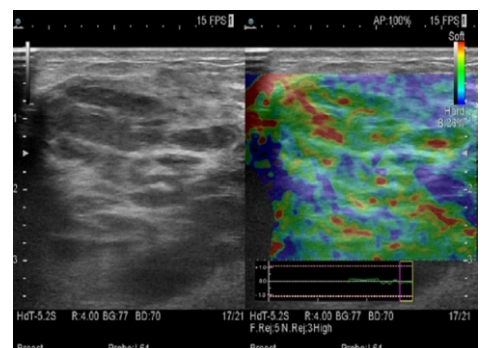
Patient with severe breast tenderness and fever USG breast showing diffusely heterogenous mass lesion. Inflamed breast tissue, increased vascularity on Doppler and mostly red, green color identified centrally and stiff tissue peripherally on elastography scale suggestive of Mastitis.
